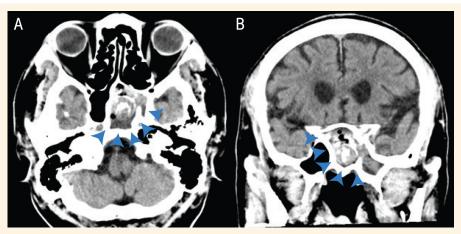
Axial (A) and coronal (B) planes of plain cranial computed tomography demonstrating a soft tissue mass with abnormal high-density calcifications in the left sphenoid sinus (blue arrowheads).
